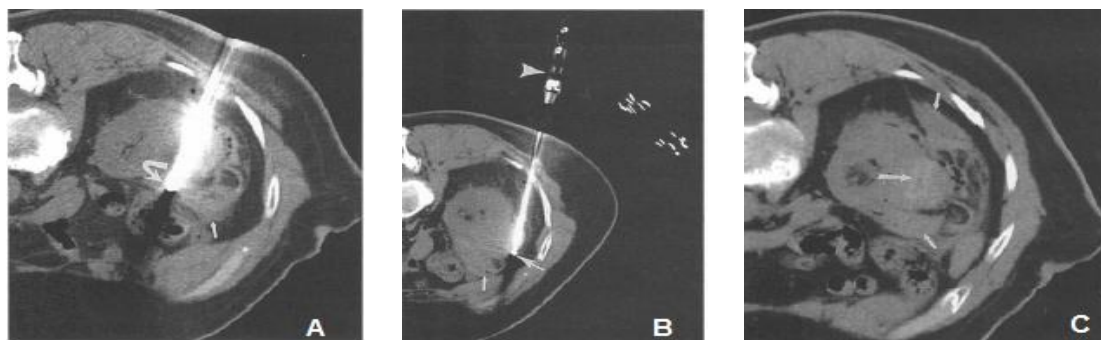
CT during and immediately after RFA. (A) CT with the patient in prone position, shows electrode (curved arrow) near the medial margin of the tumor. A small amount of hemorrhage (small arrow) separates the tumor from the colon. (B) CT scan shows the electrode (arrow) repositioned in the lower lateral portion of the tumor. Again, we visualized a small amount of hemorrhage (small arrow) above. By positioning the patient for CT-guided RFA, the operator must leave enough space for the patient and to manage the electrode inside the gantry. (C) CT scan done after retired the electrodes and the end of four consecutive ablations, shows hemorrhage anterior and posterior to the kidney (small arrows). There are air adjacent to the tumor.
